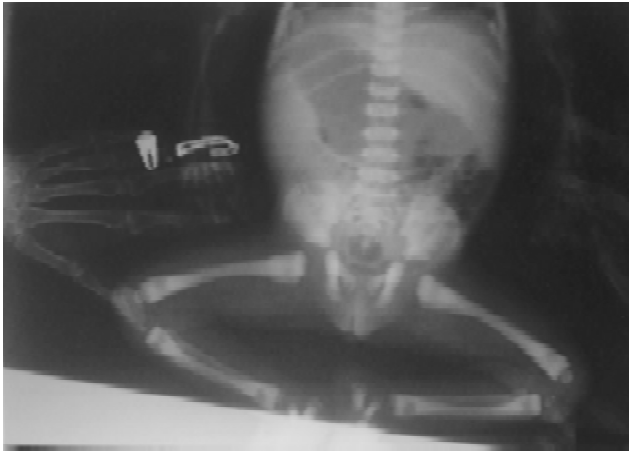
Radiograph of lower limbs and pelvis showing generalised increase in bone density and 'bone within bone' appearance
